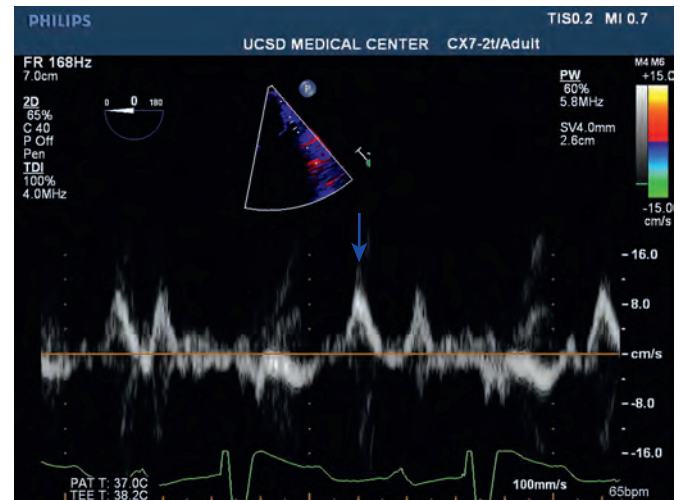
Tissue Doppler echocardiographic imaging of the lateral side of mitral annulus in the four-chamber view. The blue arrow points to the E' wave. FR, Frequency; PW, pulsed-wave; TDI, tissue Doppler image. (Courtesy University of California San Diego, La Jolla, Calif.)
